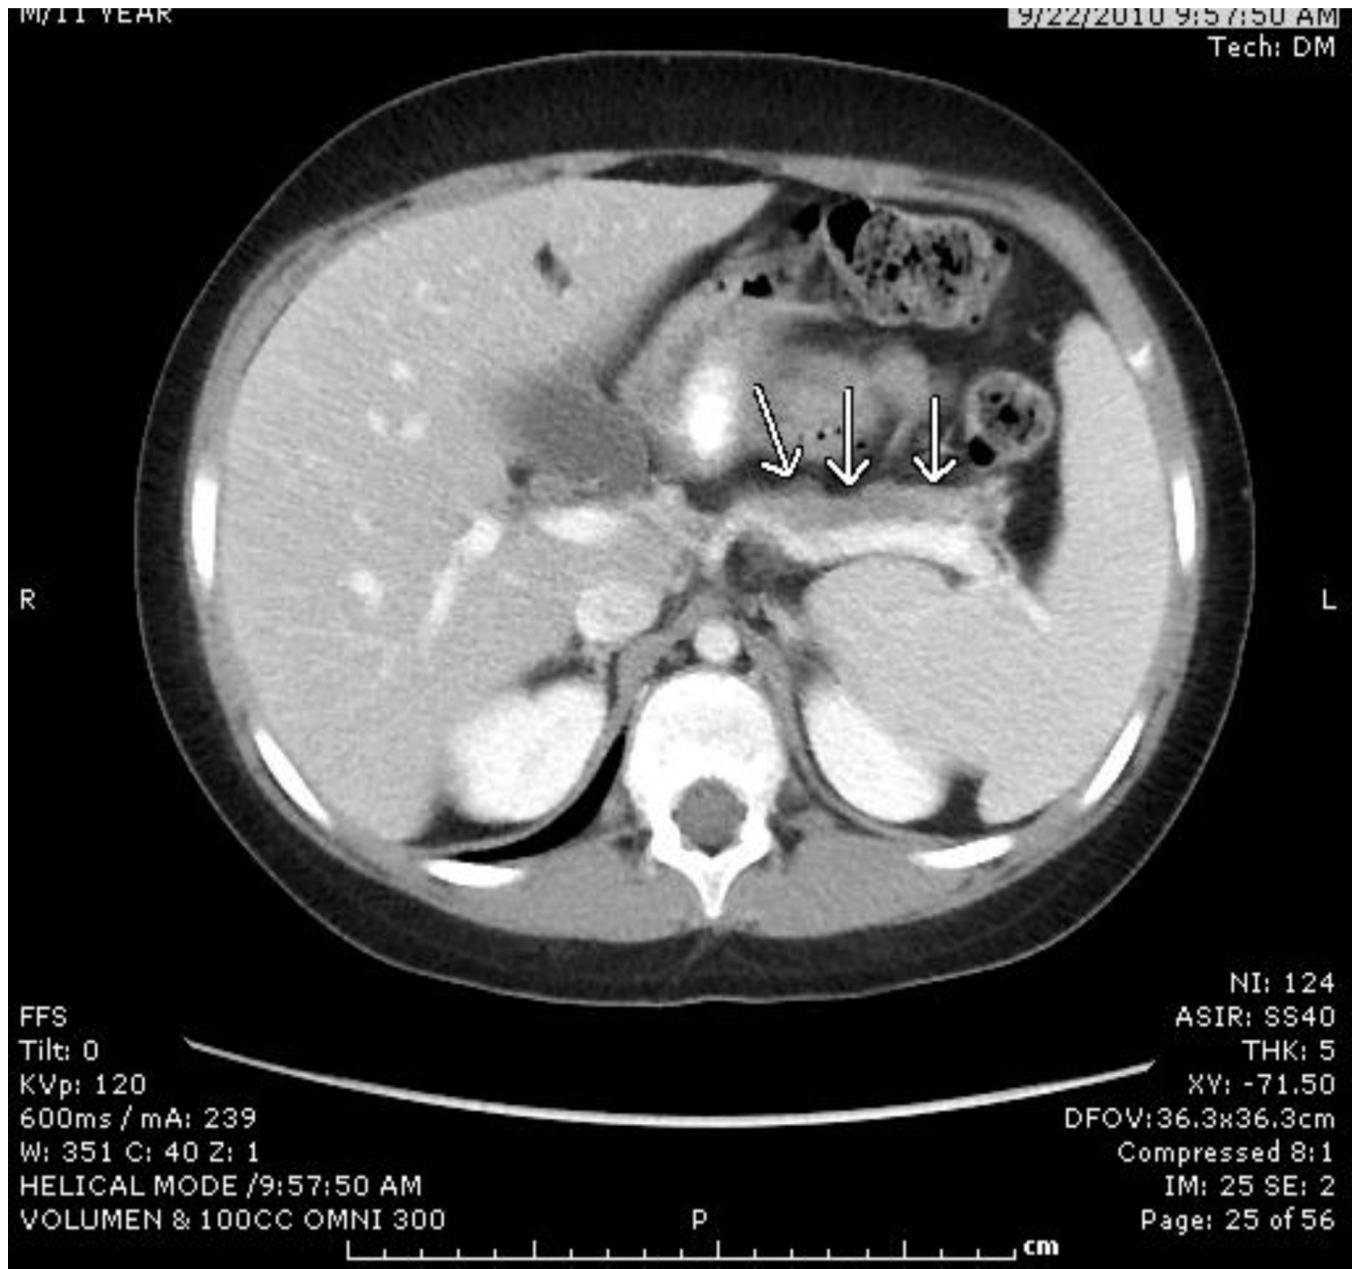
CT scan of patient 4 showing extensive atrophy of the body and tail of the pancreas (arrows) at a follow up visit 4 months following necrotizing pancreatitis.
